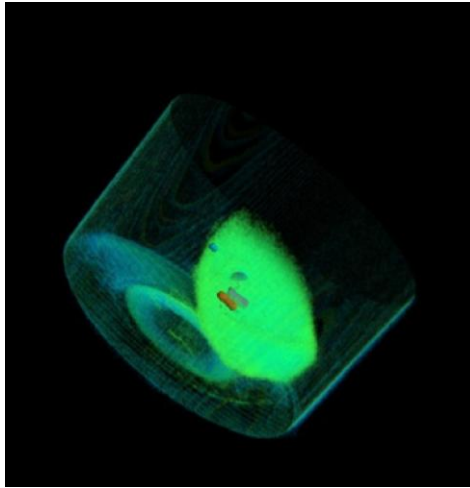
CT 3D image of kidney B with VOIs (volumes of interest). The image shows only the volumes with high attenuation from a certain value of CT
